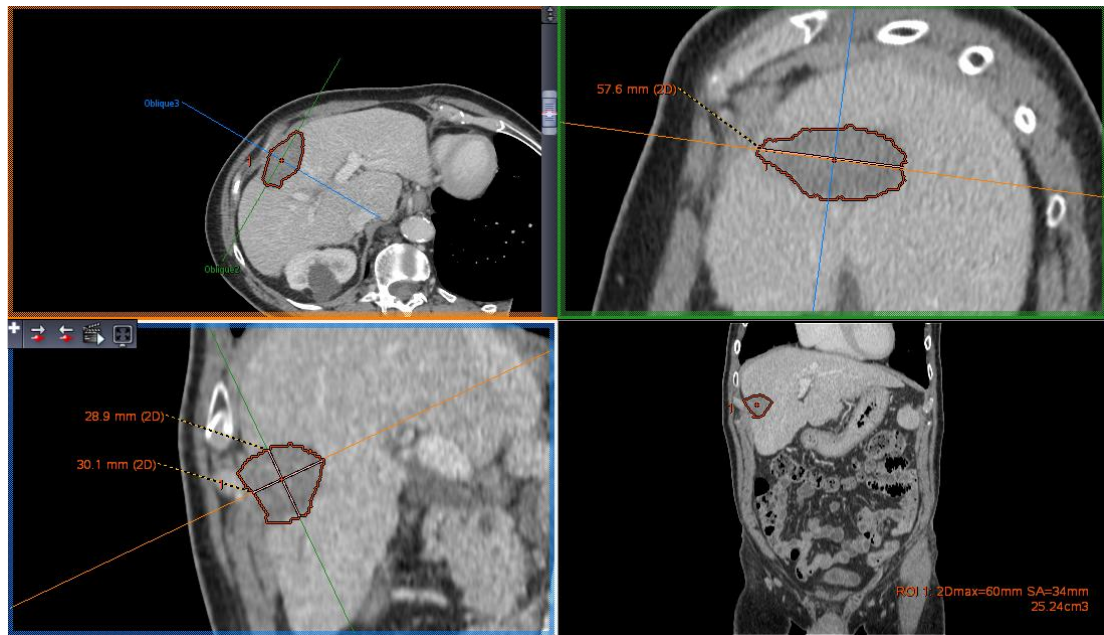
(Supplementary): Each ablation zone was semiautomatically segmented and the volume calculated automatically. The line of segmentation followed the border between the unenhanced ablated tissue and the surrounding, enhancing parenchyma. A 1-month portal phase CT scan images were used in all but two patients. For these two patients, the MRI images were used in a similar fashion. Three corresponding diameters were manually determined from multiplanar reconstruction following the applicator track.
